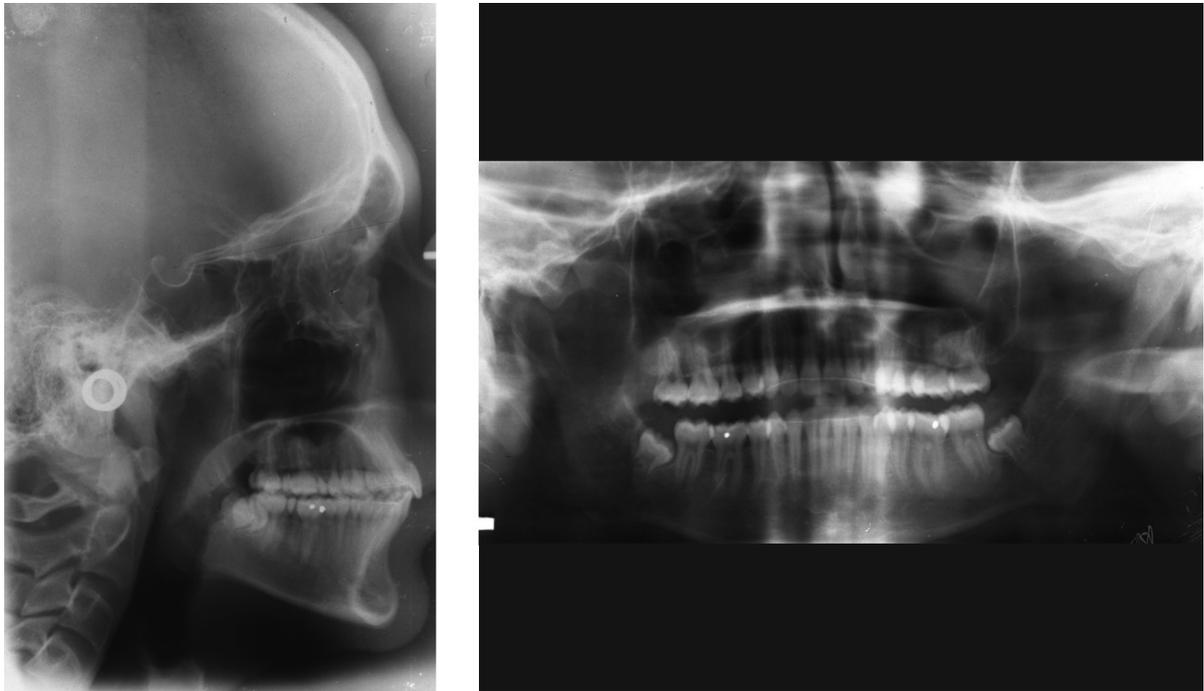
A - B, Post Treatment Radiographs
